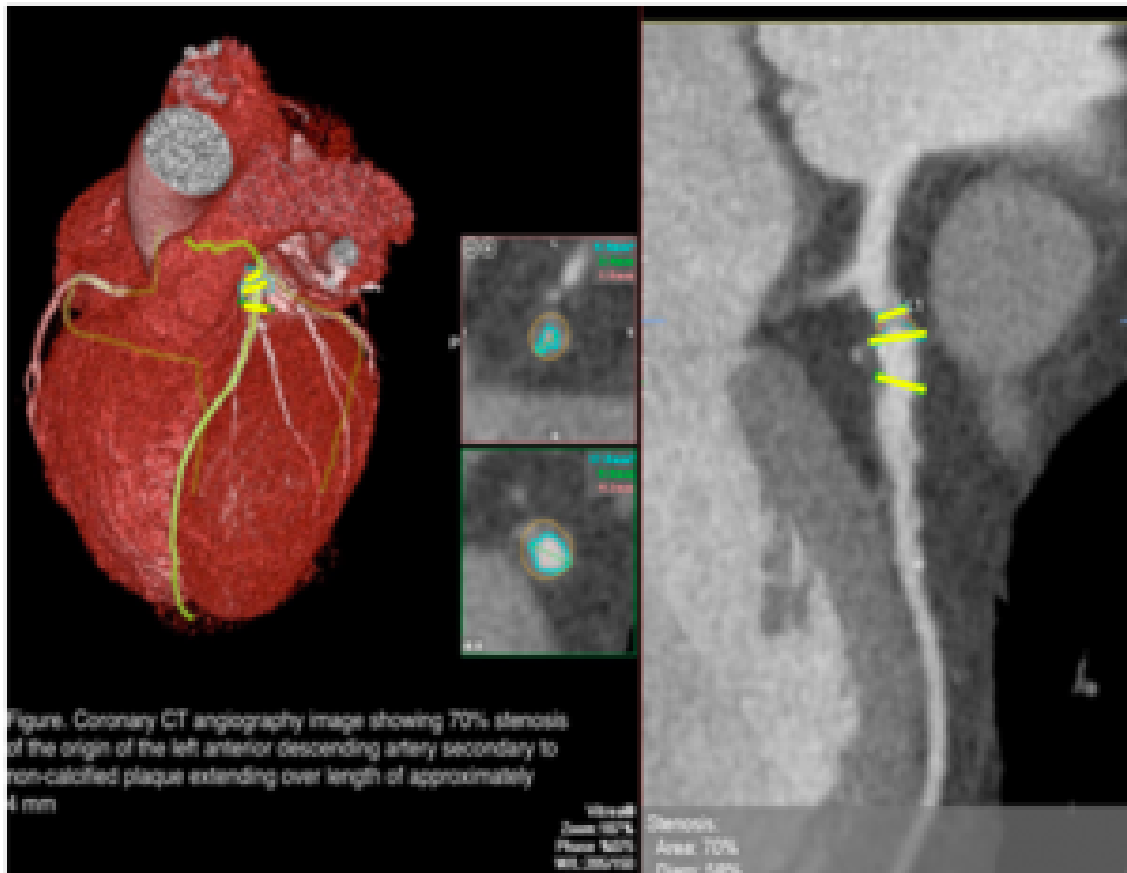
Imaging from the coronary computed tomography angiography showing 70% stenosis of “the origin of the left anterior descending artery to secondary to non-calcified plaque extending over a length of approximately 4 mm” (yellow lines).¹
